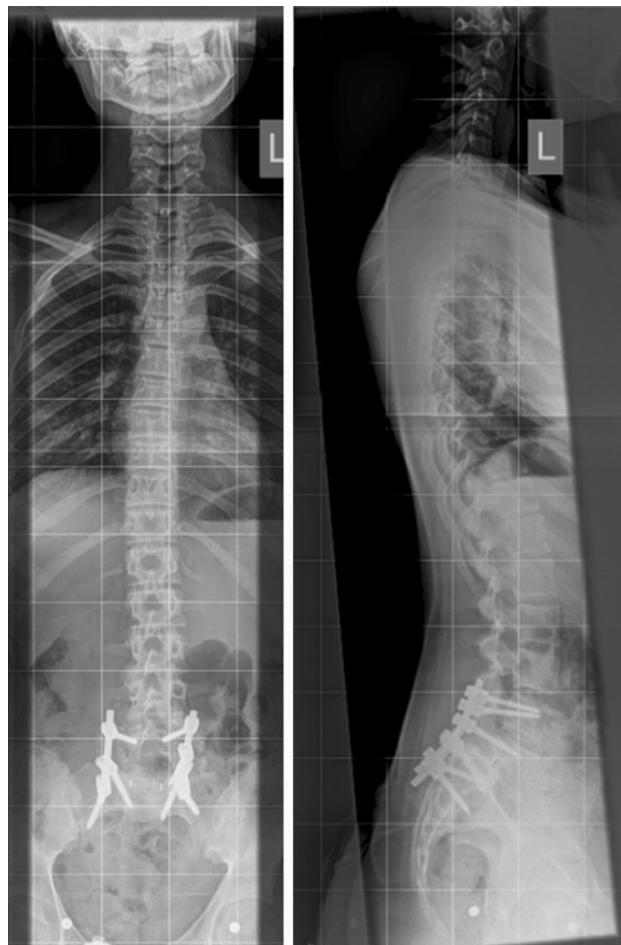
Standing AP and lateral radiographs showing resolution of the scoliosis
